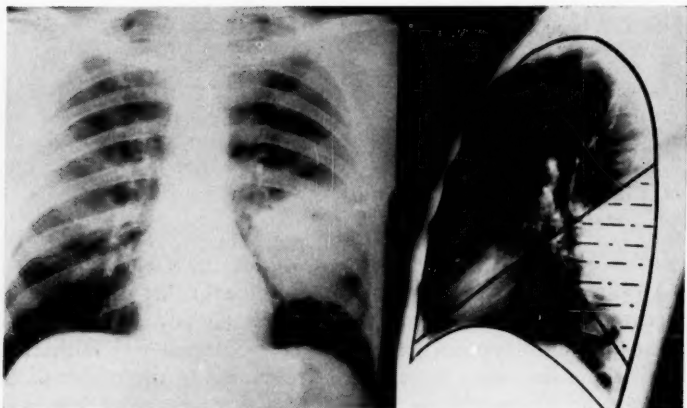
X-ray films showing pulmonary abscess, localized to superior segment of left lower lobe. This is a common site of abscess.
